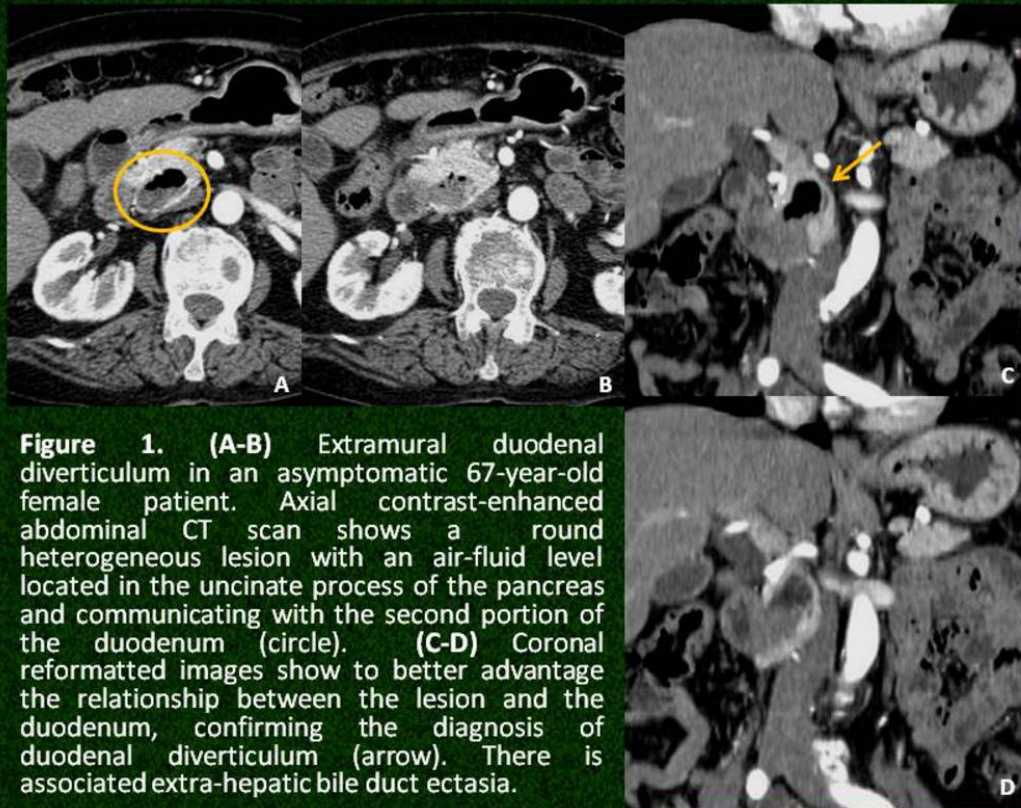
Extramural Diverticulum - CT
